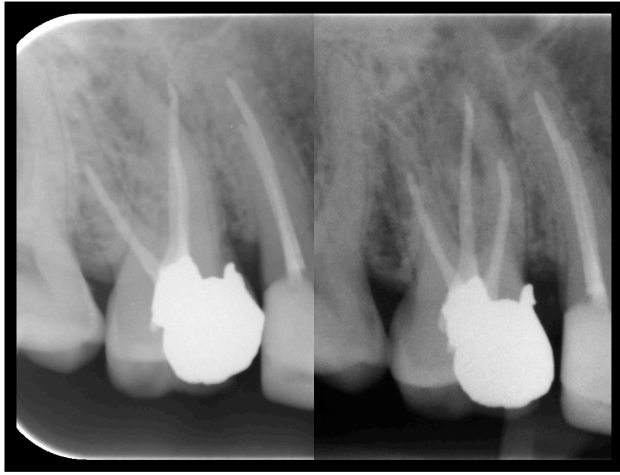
Pretreatment radiographs, left is mesioangulated
